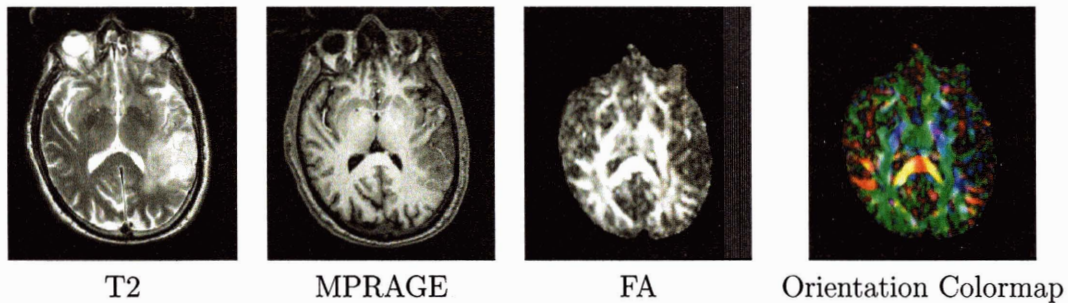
Slice-based DTI visualization of patient 1. The left two images are MRI structural images. The tumor (and surrounding edema) are bright in the T2 image, and the tumor is dark in the MPRAGE image. The FA image shows the diffusion anisotropy. The orientation colormap displays the direction of the major eigenvector of the tensor: red represents left-right orientation, green is anterior-posterior, and blue is superior-inferior. Brightness of the colormap is controlled by anisotropy. Decreased brightness is seen in the tumor area, indicating abnormal white matter.
